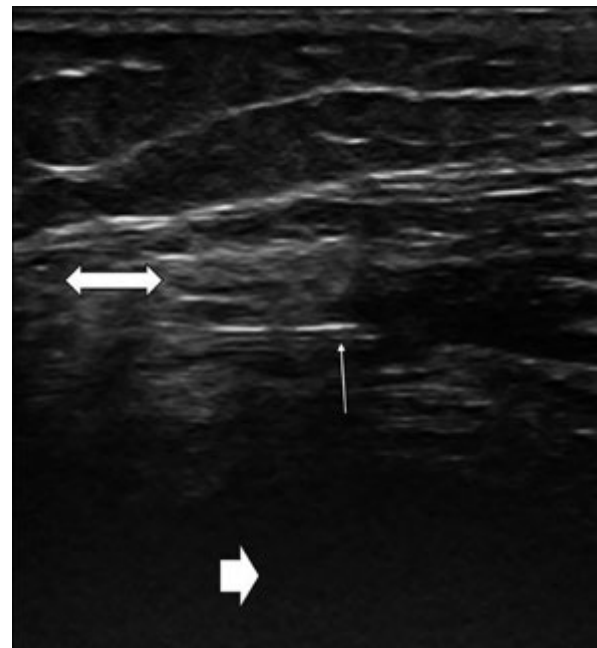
Image presents ultrasound confirmation of needle position during radiosynoviorthesis of the knee joint. Double-sided arrow – synovium; slim arrow – end of needle; short right-sided arrow – femur.
